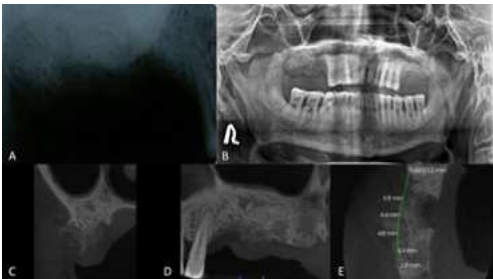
Radiographic views: A. Intraoral periapical radiograph, B. Orthopantomograph (OPG), C. CBCT- Coronal section, D. CBCT-Sagittal section and E. CBCT-Axial section.
